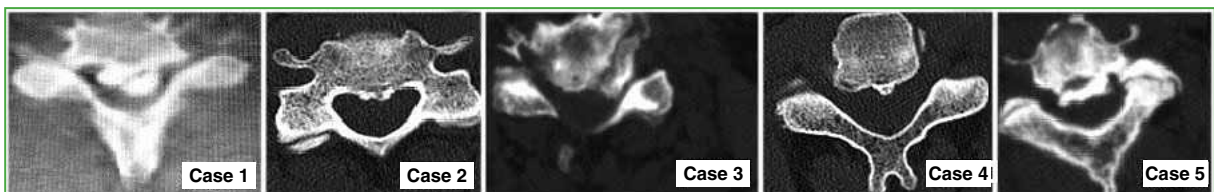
Computed tomography, axial plane. Cases 1-5. Images compatible with ossification of the posterior longitudinal ligament.
